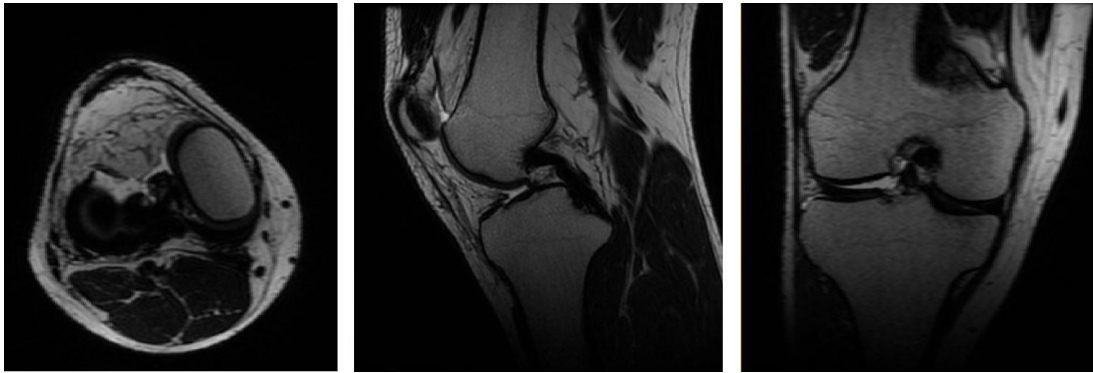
The high-resolution MRI of the right knee from axial, sagittal, and coronal views.
